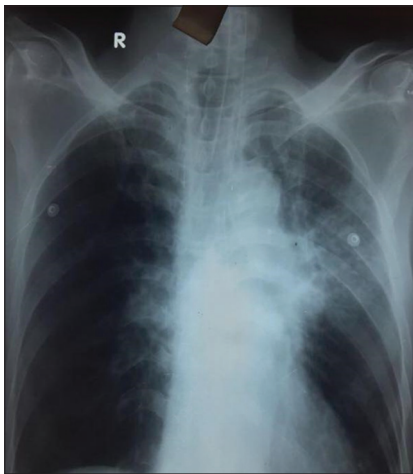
Chest X-ray showing a small area of consolidation in the left lung
